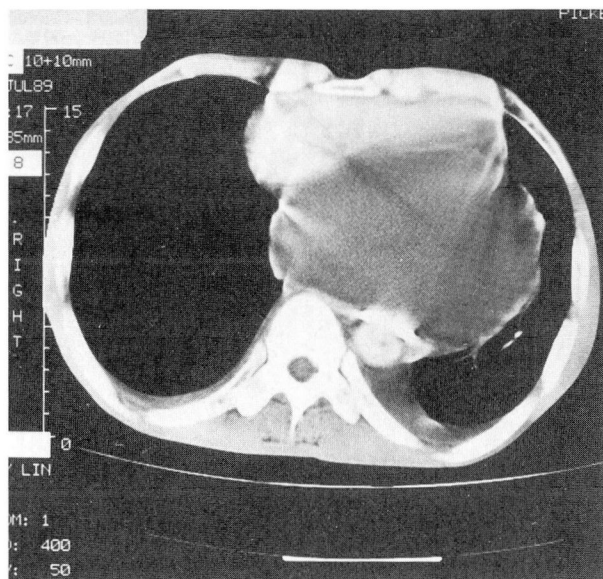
Computed tomographic scan of the lower thorax. A posterior mediastinal pancreatic pseudocyst compresses the heart.
